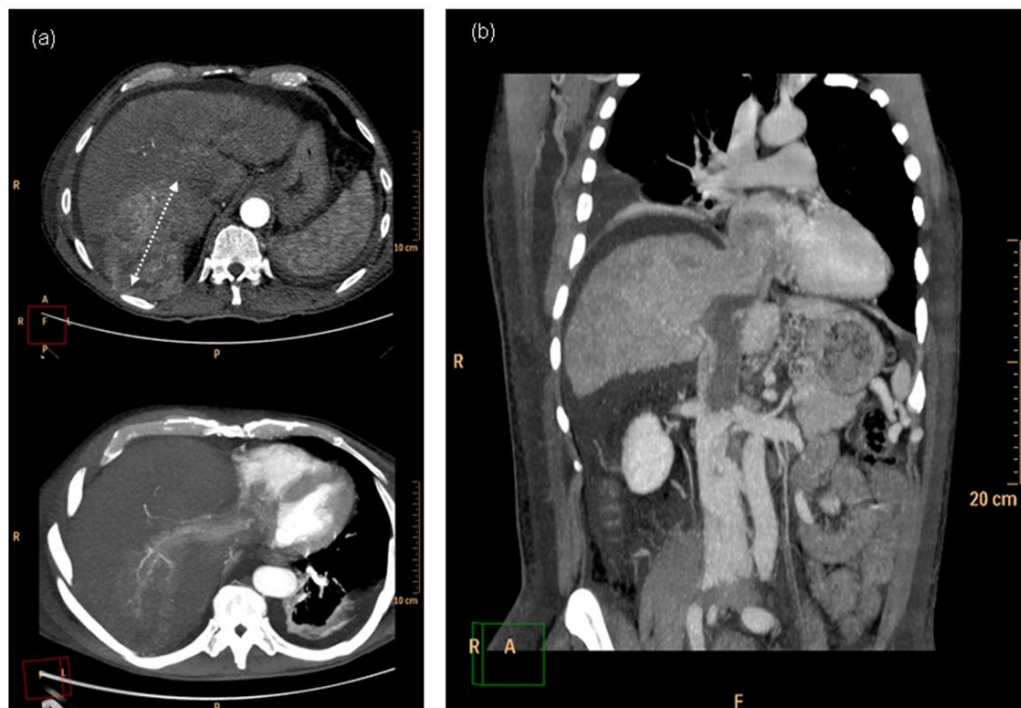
Computed Tomography axial (a) and frontal (b) sections showing a highly-vascularized hepatic tumor on liver cirrhosis, compatible with Hepatocellular Carcinoma, complicated with ascites and tumoral thrombosis extension to the Inferior Vena Cava and right atrium.
